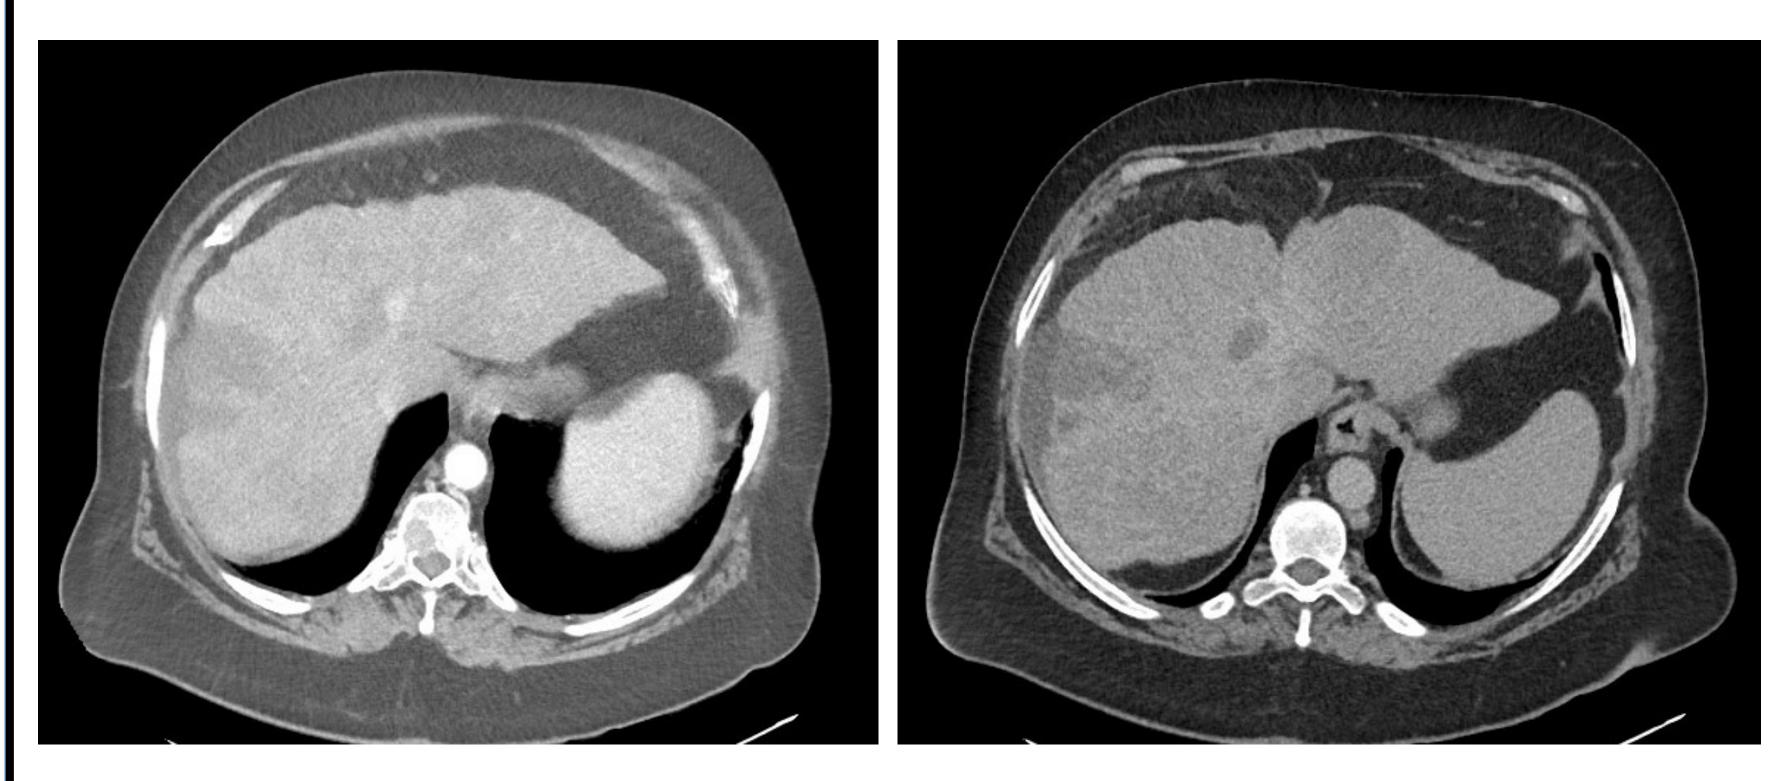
Triple Phase CT Abdomen/Pelvis: New liver lesions in multiple segments, enlarged LN in the porta hepatis, widespread spinal lytic lesions
